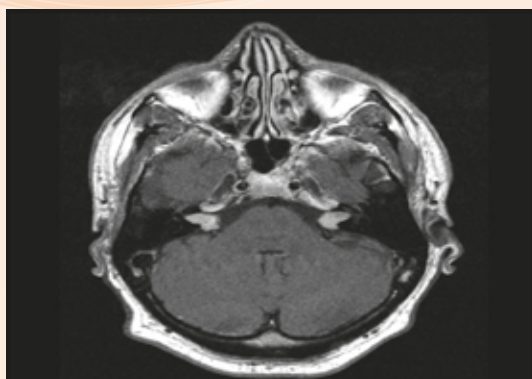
An MRI showing bilateral acoustic neuromas.
